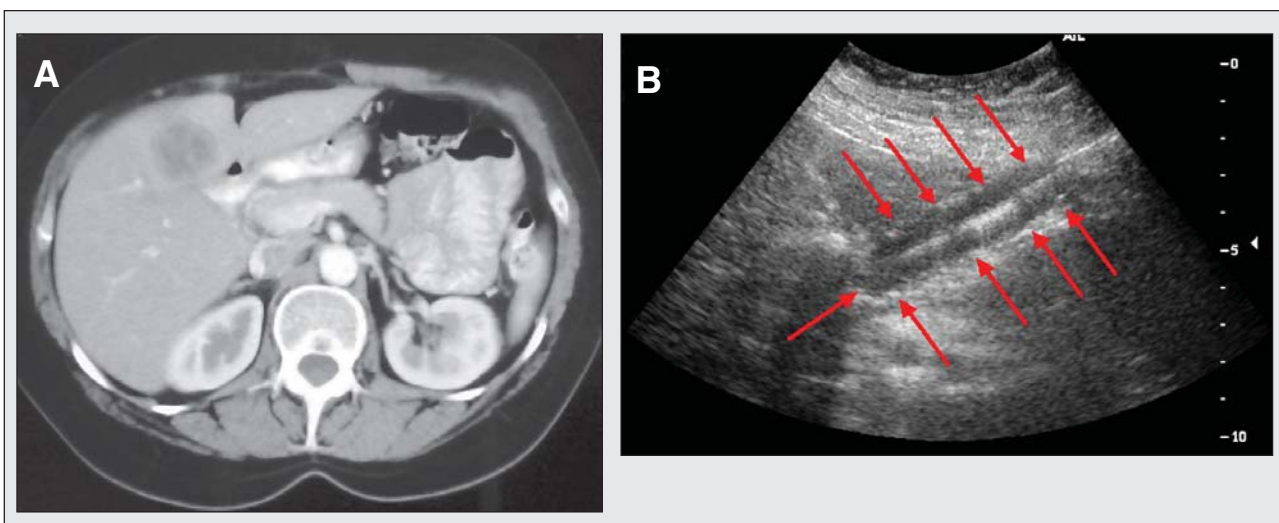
Percutaneous Cryoablation—(A) CT scan shows liver metastases immediately adjacent to duodenum. (B) Balloon (arrows) placed percutaneously using ultrasound guidance allowed separation of liver from duodenum with resultant safe percutaneous cryoablation of liver metastasis.
